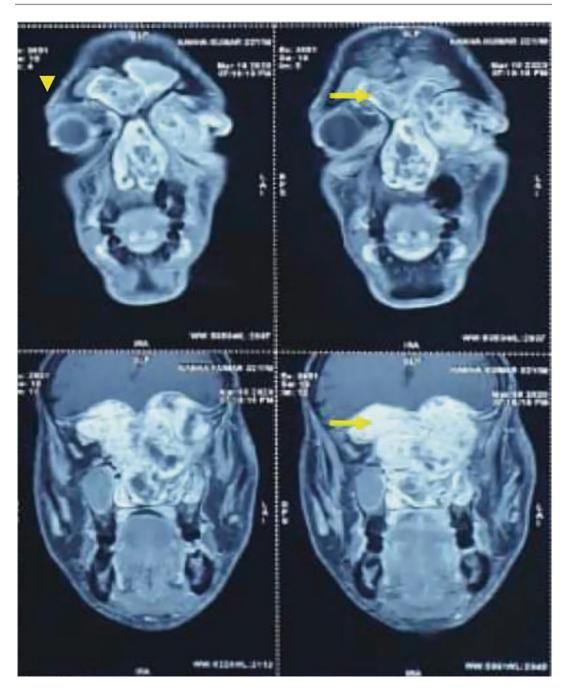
MRI scan: a coronal plane shows the lesion with intracranial extension
